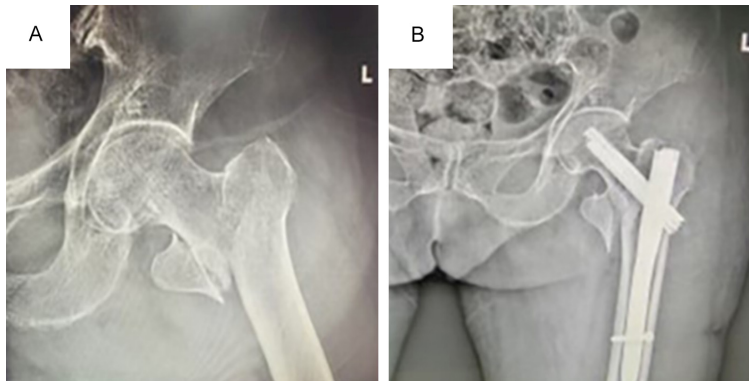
Representative radiographs of an elderly patient with a left intertrochanteric femoral fracture. A. Preoperative X-ray showing a left intertrochanteric femoral fracture. B. Postoperative X-ray obtained one week after closed reduction and intramedullary nail fixation, demonstrating satisfactory fracture reduction and proper positioning of the internal fixation device.
